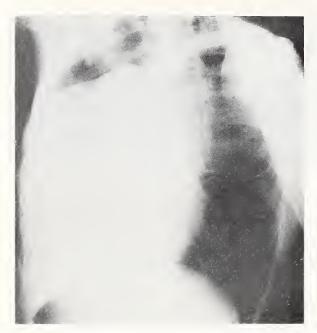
Roentgenogram of chest before surgery.
